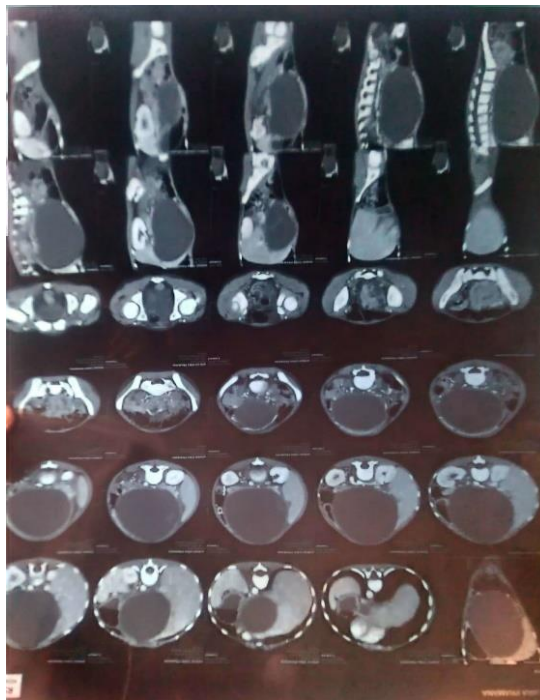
Abdominal CT-scan with contrast
